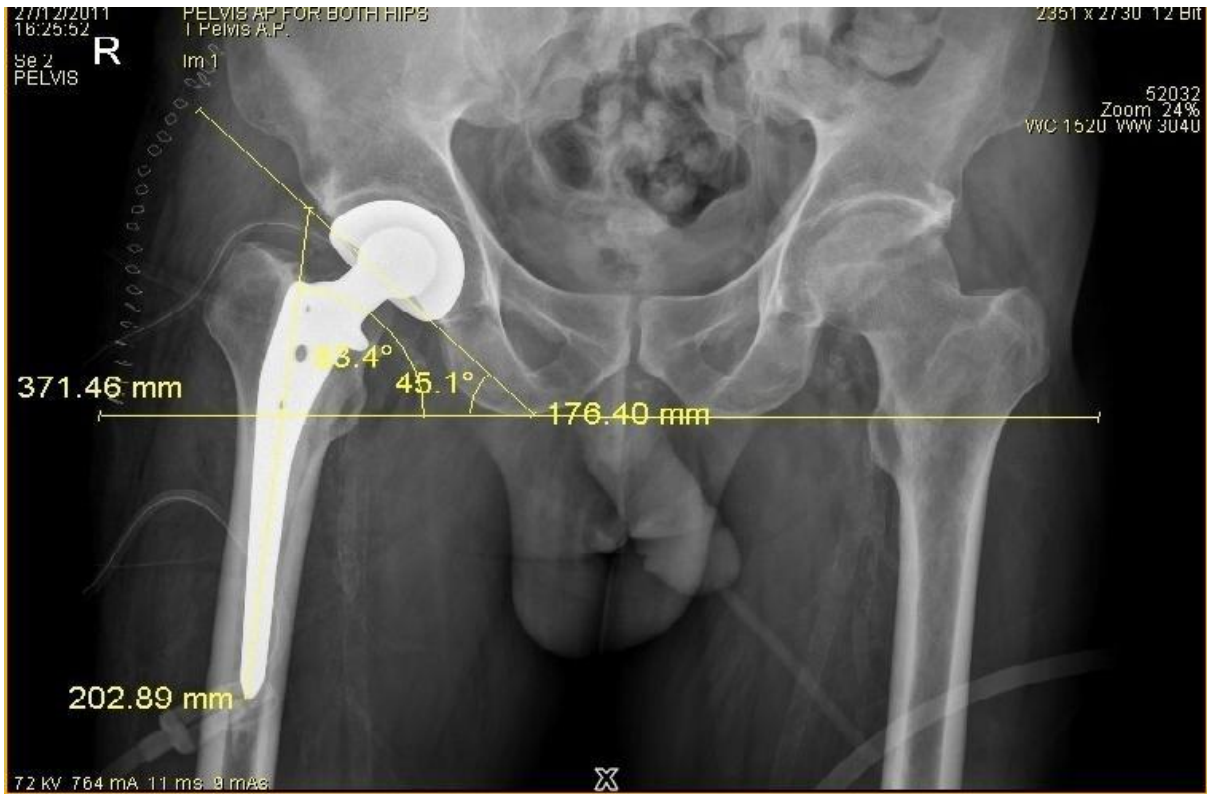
X-ray of pelvis with both hips (neutral position) with Bipolar prosthesis on right side showing
